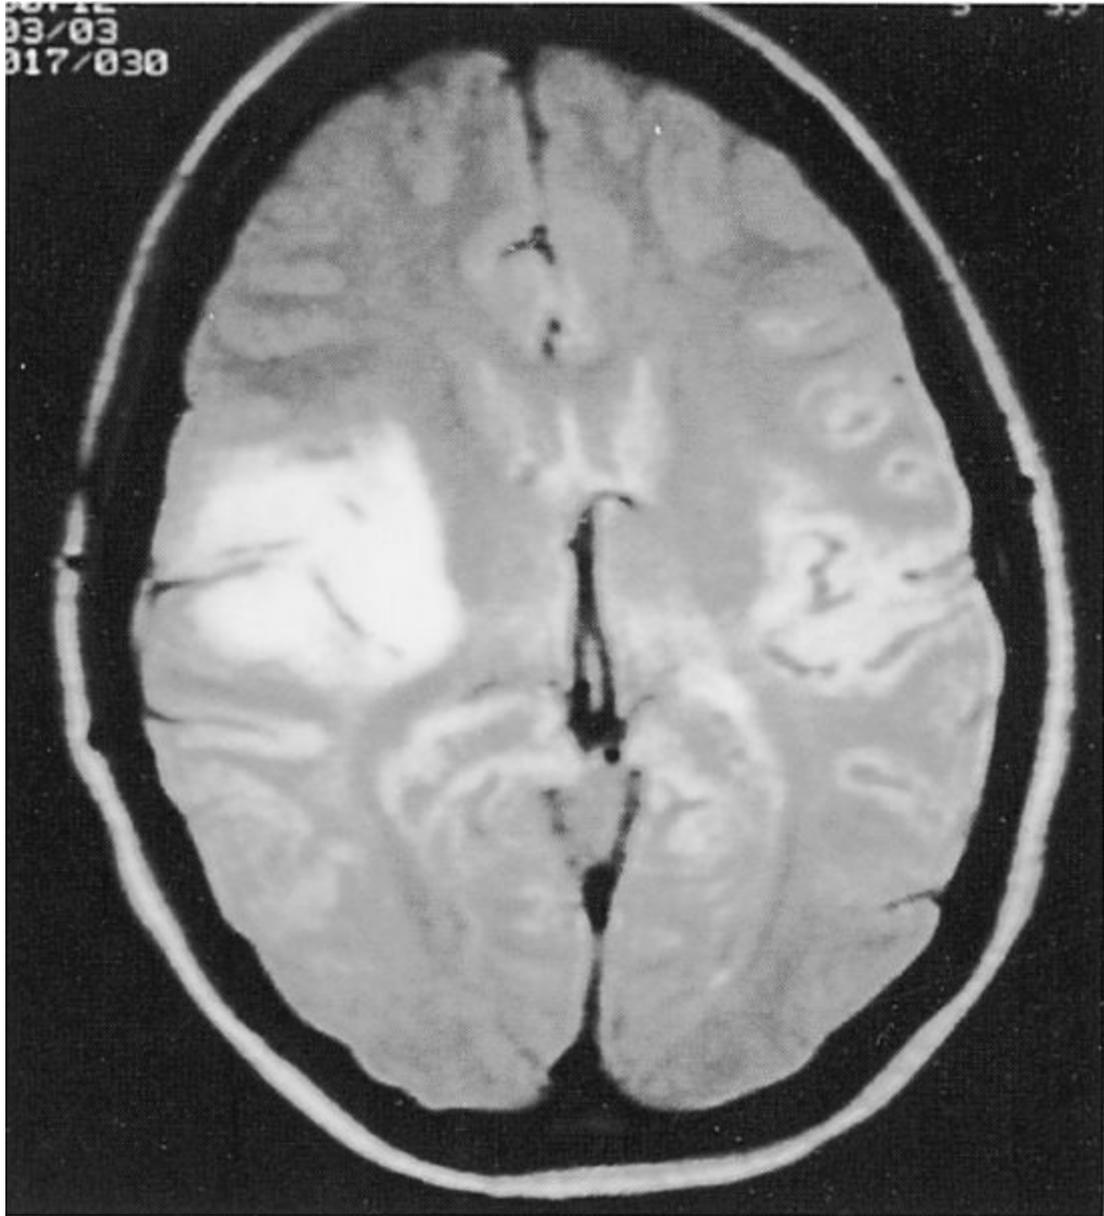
Low-grade glioma. Magnetic resonance imaging (MRI) of the brain shows an abnormal density in the right temporal lobe. (Courtesy of the Hospital of the University of Pennsylvania, Nuclear Medicine Section, Philadelphia, PA.)
